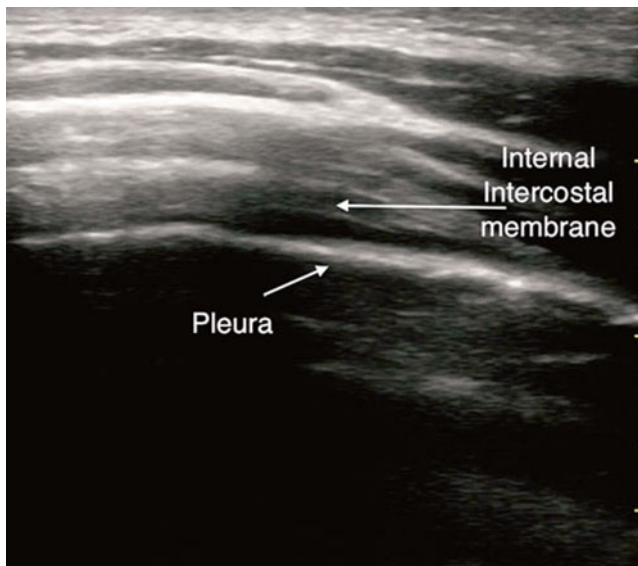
Tilting ultrasound probe will allow a view of intercostal muscles and pleura
